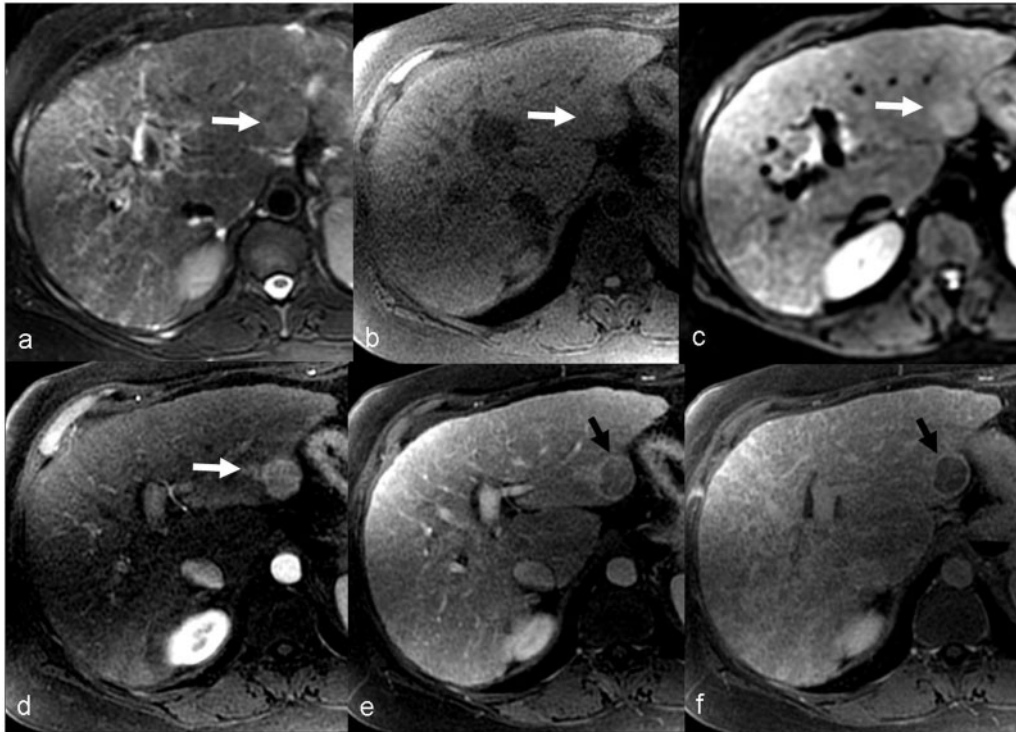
MRI of HCC in a 54-year-old woman with chronic hepatitis C. HCC (white arrow) appears mildly hyperintense to liver on the T2-weighted image (a), hypo- to isointense on the T1-weighted image, shows restricted diffusion on DWI (c), arterial phase enhancement (d) and washout in both portal venous (e) and delayed (f) phases. Note the enhancing capsule (black arrow) in both portal venous and delayed phases.
